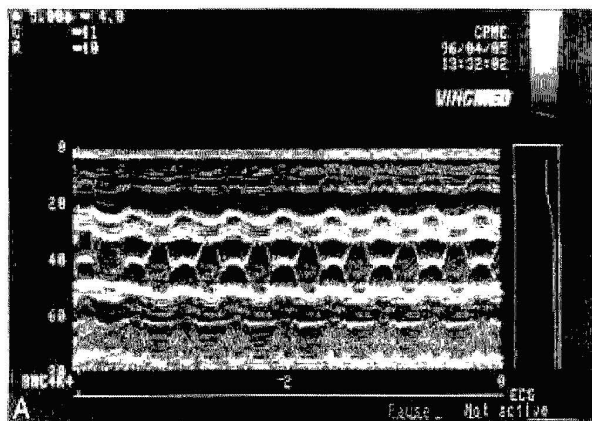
(A) m-Mode echocardiogram demonstrates full opening and closing of the leaflets. (B) Long axis view with trace regurgitation during diastole represented by the mosaic pattern at the center of the valve. No perivalvular leak is observed.
